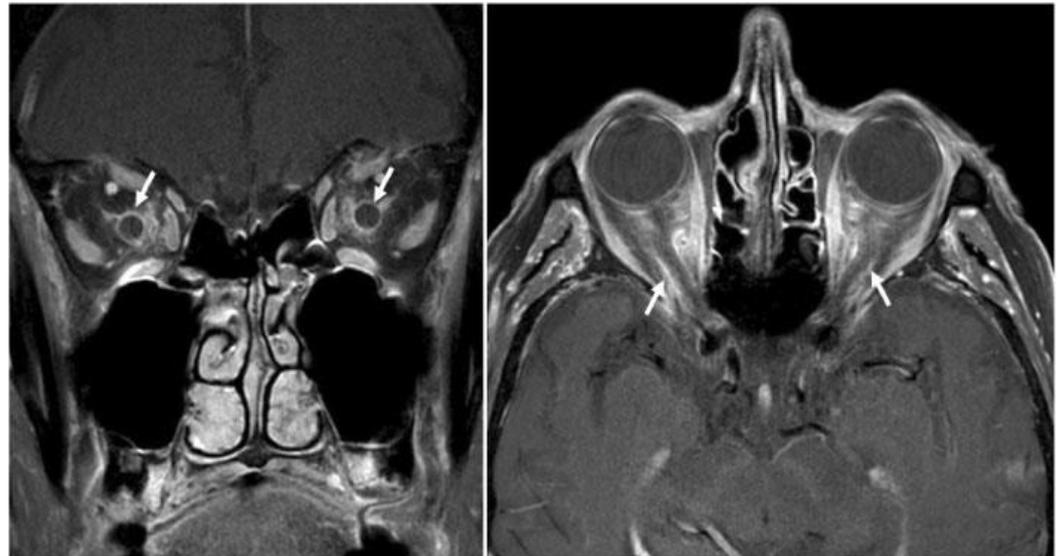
Coronal and axial contrast-enhanced T1-weighted fat-suppressed MRI of the orbits indicating optic nerve sheaths enhancement (white arrows).[14]
